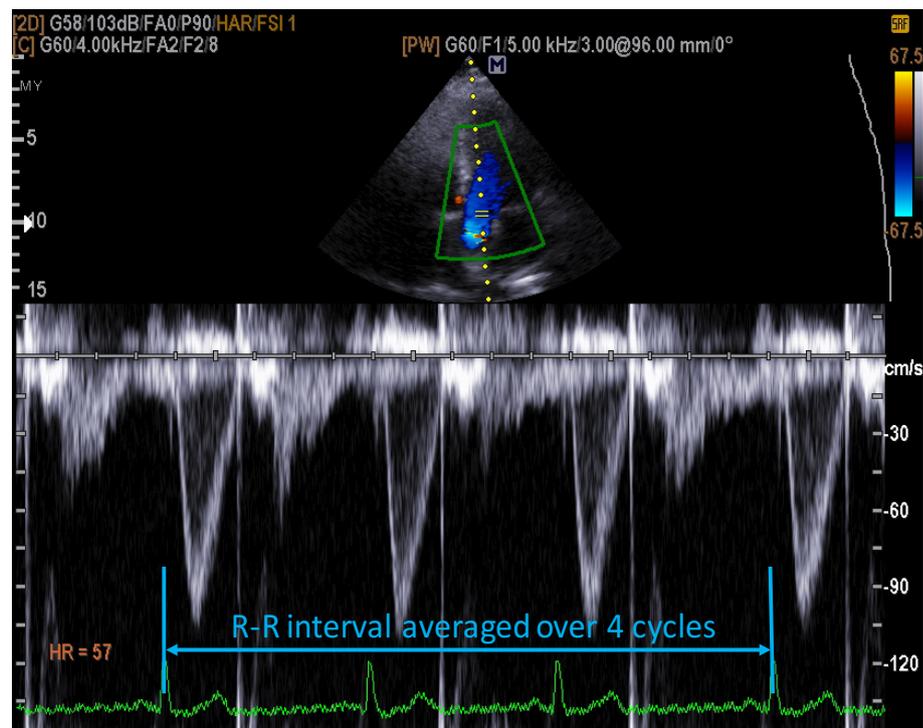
PW Doppler R-R interval averaged over 4 cycles
